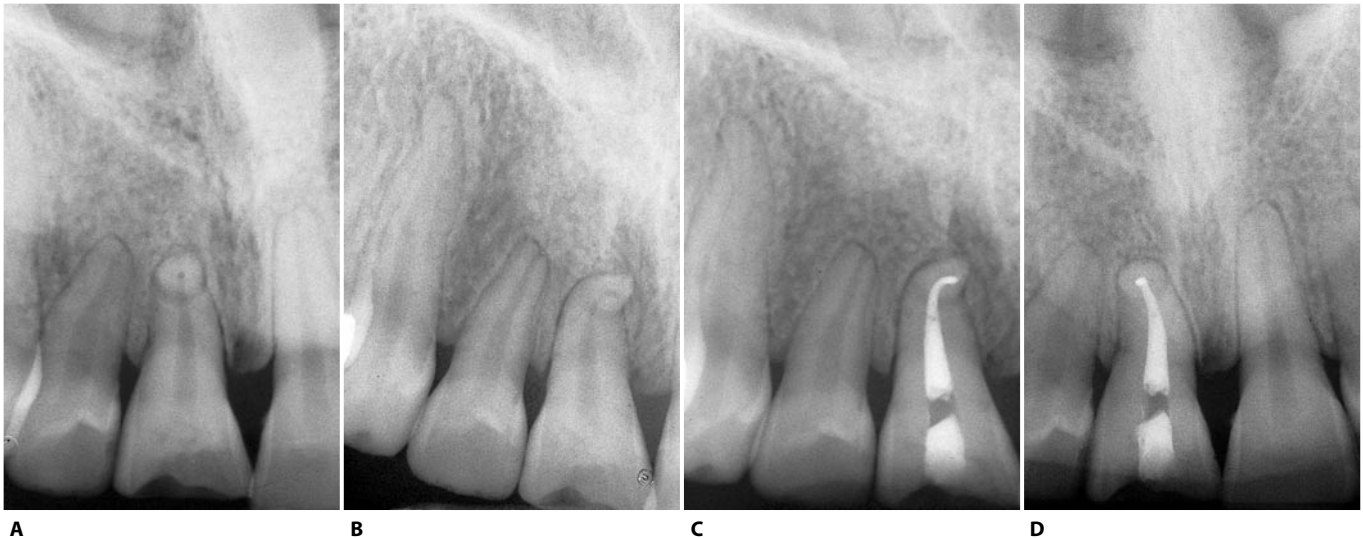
A. Preoperative radiograph of the upper right central incisor. The apical foramen rests on the same plane as the path of X-rays: it could be facing buccally or palatally. B. A second radiograph with a distomesial angulation reveals that the curve faces buccally. Endodontic therapy has been completed, keeping this angulation, which in this case also allows the visualization of the radiographic terminus of the canal. C. Postoperative radiograph. Note that only with this angulation does the small endodontic lesion at the level of the root apex become visible. D. Post-operative radiograph performed in standard projection. Note that the filling can seem short by almost 2 mm and the lesion already healed!
